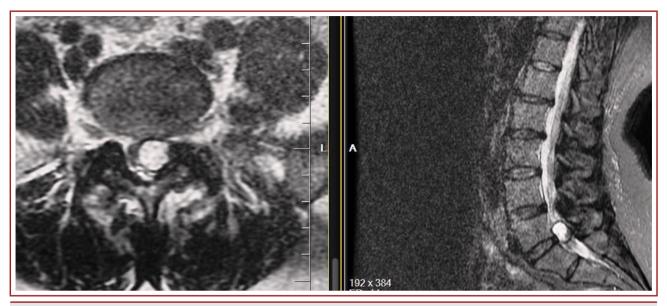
There was round shaped, cystic and heterogenic lesion pressing on the S1 root that appeared hyper intense on the T1 and T2-weighted lumbar MR images.
